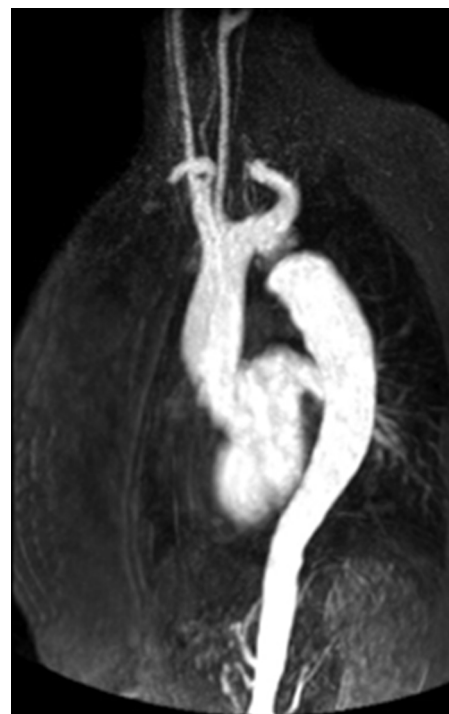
MRI angiography with maximum intensity projection reconstruction of a pseudo-coarctation due to excessive length of the aortic arch and the first part of the ascending aorta, resulting in a folding or *kinking* immediately next to the arterial ligament.
